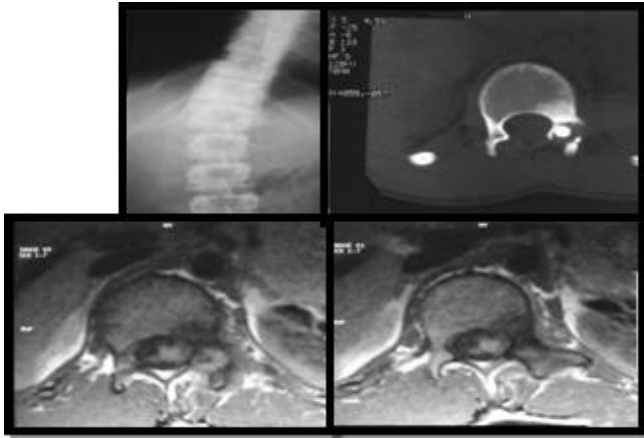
(Case 3): A-P Radiograph showing scoliosis. CT axial sections showing a mixed lytic & sclerotic lesion in L1 left pedicle. T1W MR Images showing a focal low signal in L1 left pedicle with diffuse low signal intensity bone edema.
